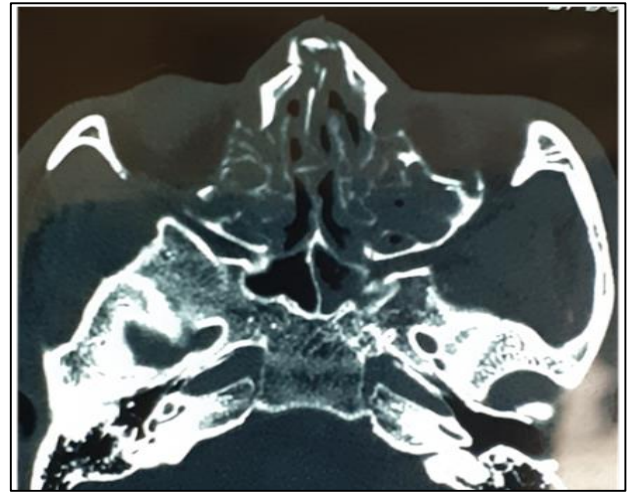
CT scan showing nasal bone fracture.
